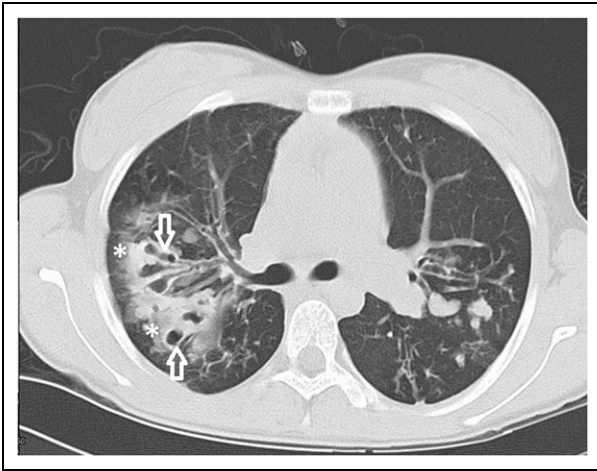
Chest computed tomographic (CT) findings. A CT image of an adolescent girl with cystic fibrosis demonstrates significant bronchiectasis (white open arrows) and mucous plugging (white asterisks).
